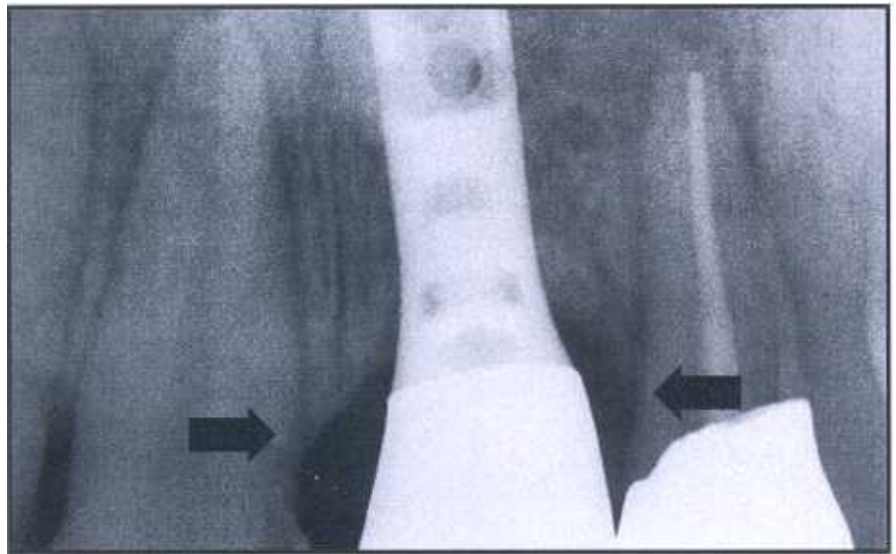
Final x-ray confirms orthodontic tissue adjustment and bone support.
